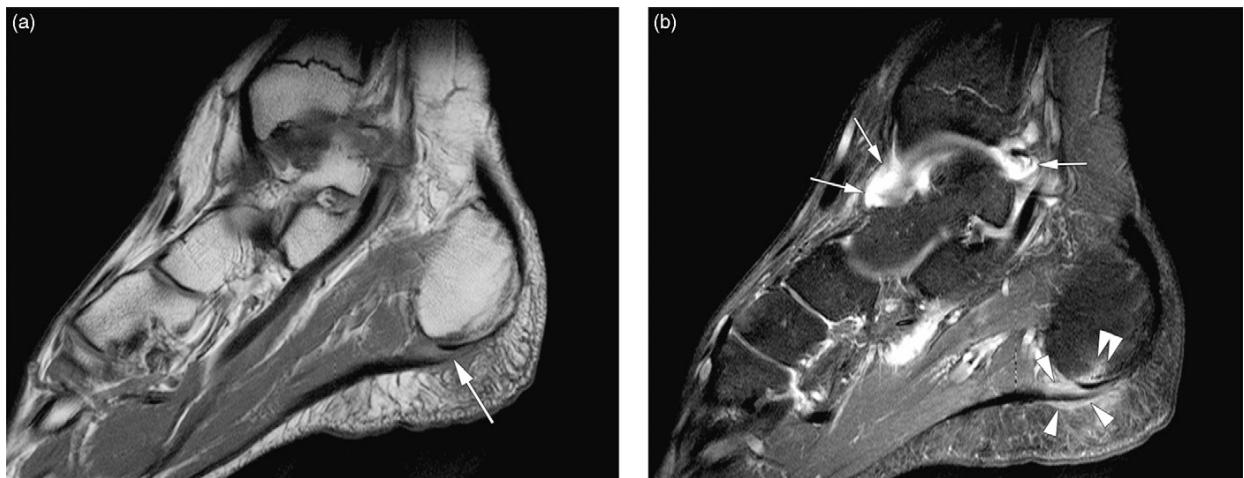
1.5 T MRI of the ankle in a 15-year-old boy with juvenile SpA. Unenhanced sagittal T1-weighted turbo spin-echo (a) and fat-suppressed T1-weighted turbo spin-echo after contrast injection (b) sequences show plantar fasciitis (arrow) with soft tissue edema (arrow heads) accompanied by calcaneal bone marrow edema (double arrowhead). Synovitis is also seen in the tibio-talar joint (small arrows).
